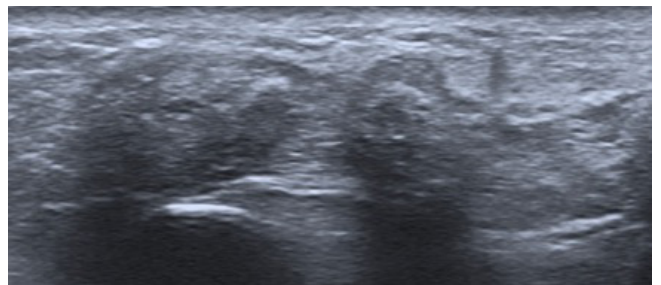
Ultrasound of the right hand shows hyperechoic content with tiny calcifications in the tenosynovium of the 3rd and 4th extensor compartments
